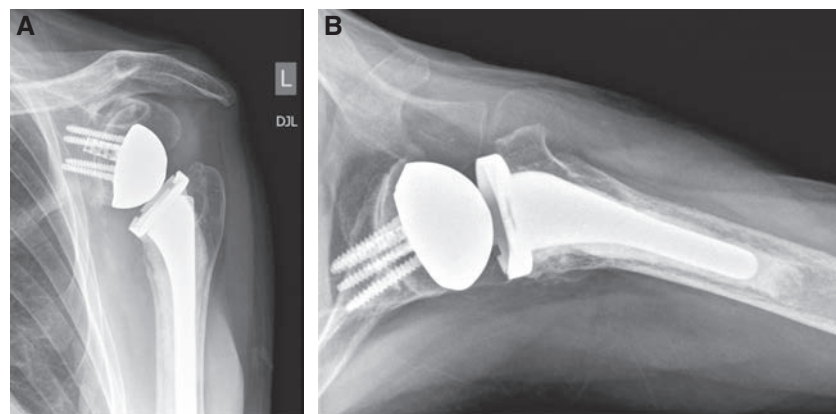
The structural graft is shown behind the glenoid baseplate in (A) anteroposterior and (B) axillary view radiographs. (The screws and cage traverse the graft into the native glenoid).
